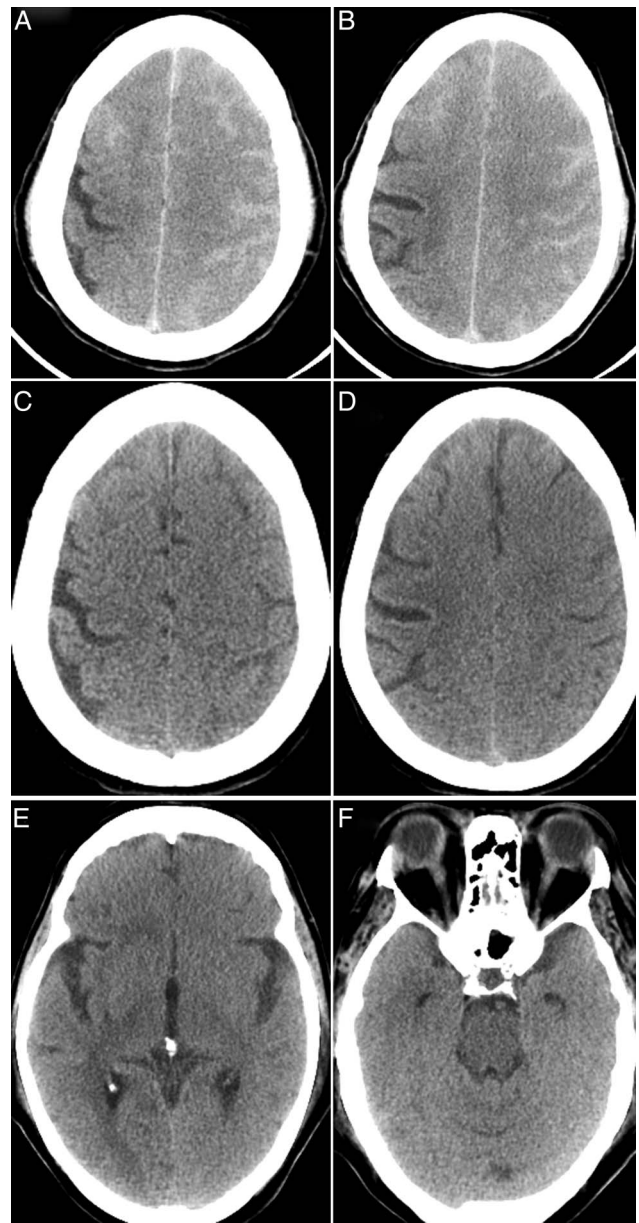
(A and B) A brain CT scan 3 h after coiling showing contrast enhancement in the territory supplied by the left internal carotid artery. There is also contrast enhancement in the distal right anterior cerebral artery (ACA) territory since the right A1 is absent. Therefore, the distal right ACA territory is also supplied by the left internal carotid artery. There is no contrast enhancement in the right middle cerebral artery territory, which is supplied by the contralateral internal carotid artery. (C and D) A brain CT scan 18 h after coiling showing complete resolution of contrast enhancement, but residual brain oedema. No subarachnoid haemorrhage can be seen. (E) No subarachnoid haemorrhage is present in the Sylvian fissures or (F) basal cisterns 18 h after coiling.
